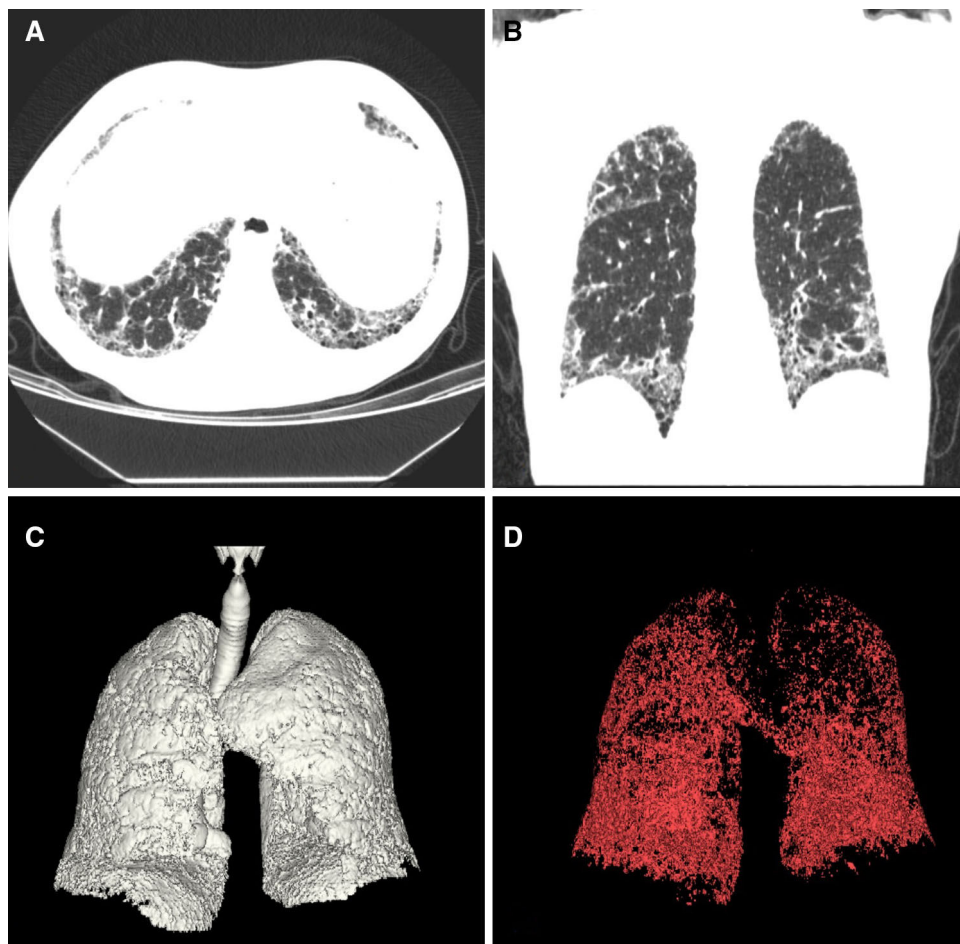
42-year-old man with scleroderma. a Axial CT image demonstrating extensive areas of ground-glass opacity and septal thickening bilaterally in the cortical zones of the lower lobes. b Axial
